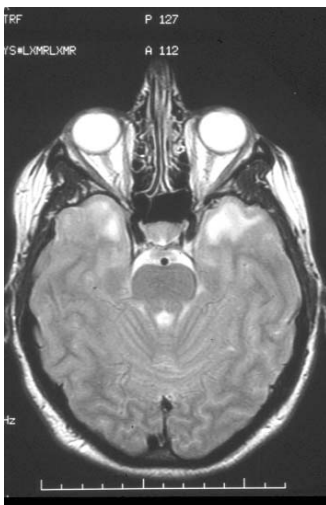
Characteristic MRI finding in a patient with CADASIL. On this FLAIR sequence high signal (leukoaraiosis) can be seen in the white matter and characteristic involvement of the anterior temporal pole is present (arrowed). (copyright with author-HM).
